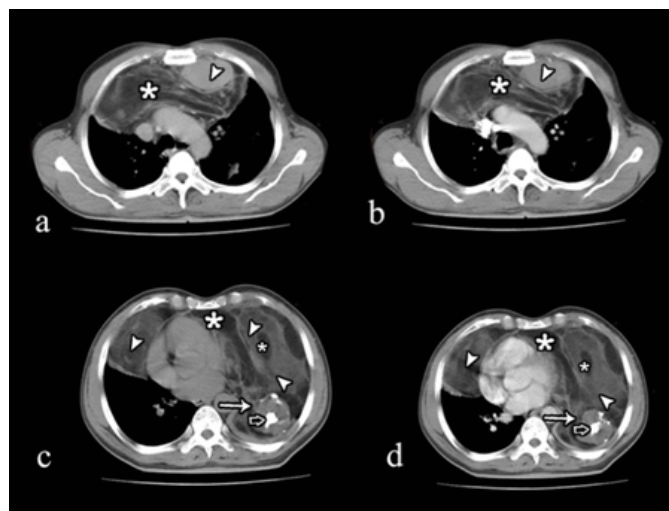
Axial computer tomography scan images of chest (a) plain and (b) contrast at the level of arch of aorta showing heterogeneous mass with fat (\*) and soft tissue (arrow head) attenuation in anterior mediastinum with mild enhancement of solid component on contrast administration. Axial CT images of chest (c) plain and (d) contrast at the level of ventricles: showing heterogeneous mass with solid component (arrow head), fat (\*), cystic areas (solid arrow) and nodular calcification (open arrow), occupying anterior half of right hemithorax and complete left hemithorax.
